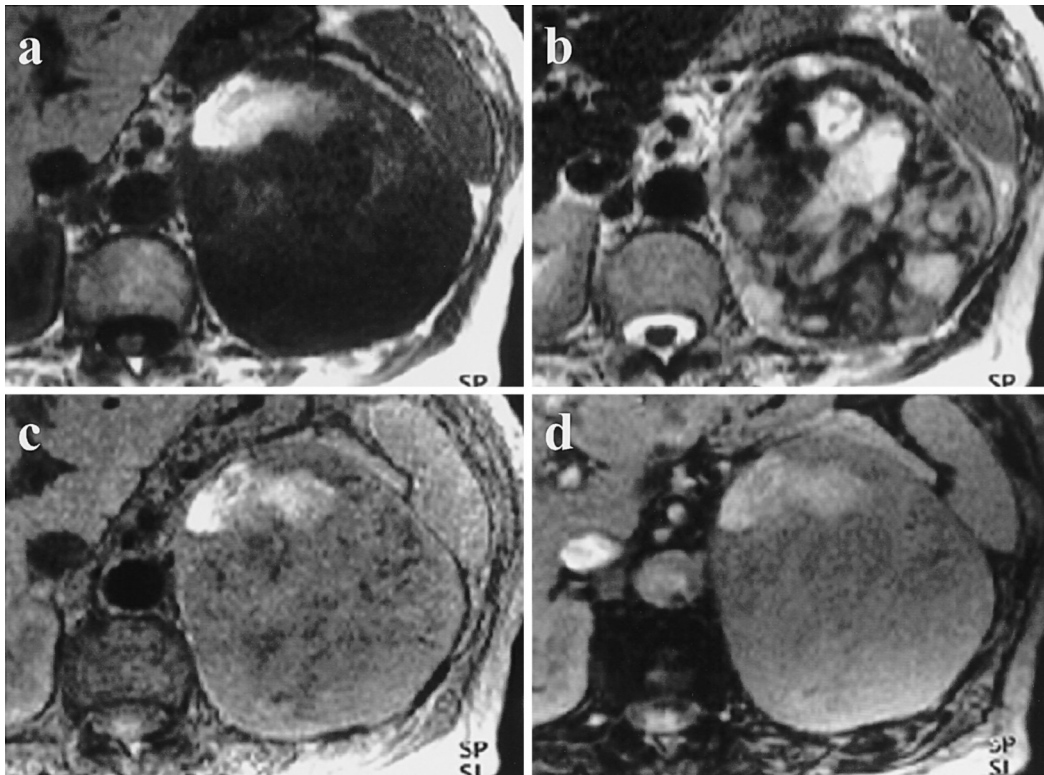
Adenoma. T1-weighted (a) and T2-weighted (b) images show a heterogeneous tumor. The area of degeneration showed high signal intensity on the T2-weighted image. In-phase (c) and opposed-phase (d) gradient echo images are also shown. The opposed-phase image did not demonstrate low signal intensity compared with the in-phase image.
